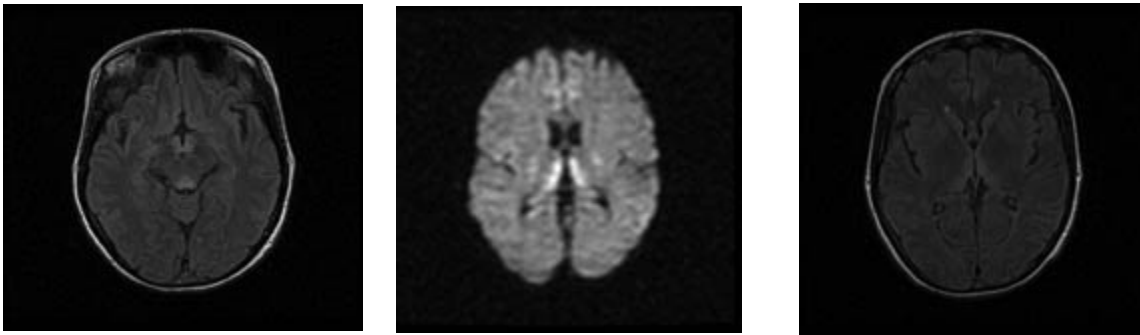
A contrast brain MRI showed hypersignal mammillary body, tegmentum and periaqueduct
